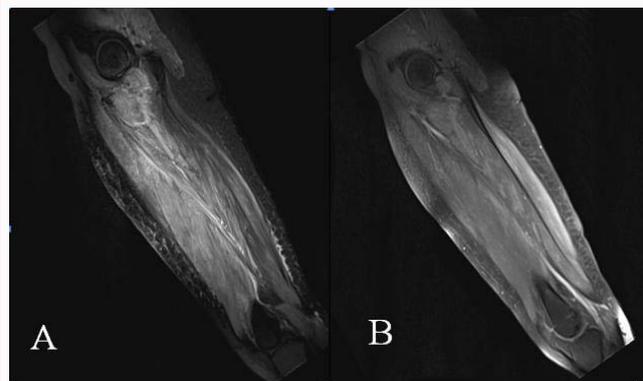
MRI of the right (A) and left (B) femur showing hyper vascularization in the subcutaneous layer bilaterally. Minimal free fluid noted in the posterior soft tissue just above the knee joints, extending to the skin.
